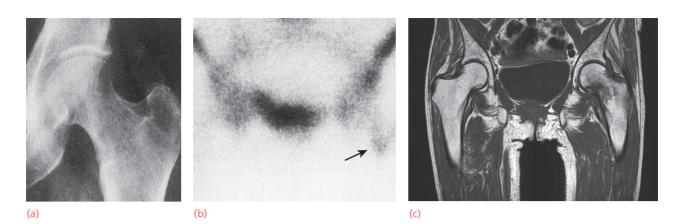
Fractures of the femoral neck – diagnosis (a) An elderly woman tripped on the pavement and complained of pain in the left hip. The plain X-ray showed no abnormality. Two weeks later she was still in pain and unable to fully weight-bear through the affected leg; (b) a bone scan showed a 'hot' area medially at the base of the femoral neck. (c) MRI of occult femoral neck fracture.
